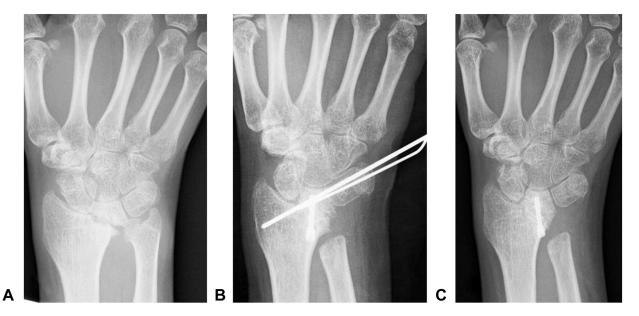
Radiographs of an RL arthrodesis technique described by Motomiya et al.¹² A Preoperative radiograph demonstrating RL arthritis. B The authors use a wire directed from the triquetrum to the radius, combined with a single headless, cannulated screw between the radius and lunate to acheive the arthrodesis. C Final post-operative radiograph demonstrating removal of the wire and fusion across the RL joint.
